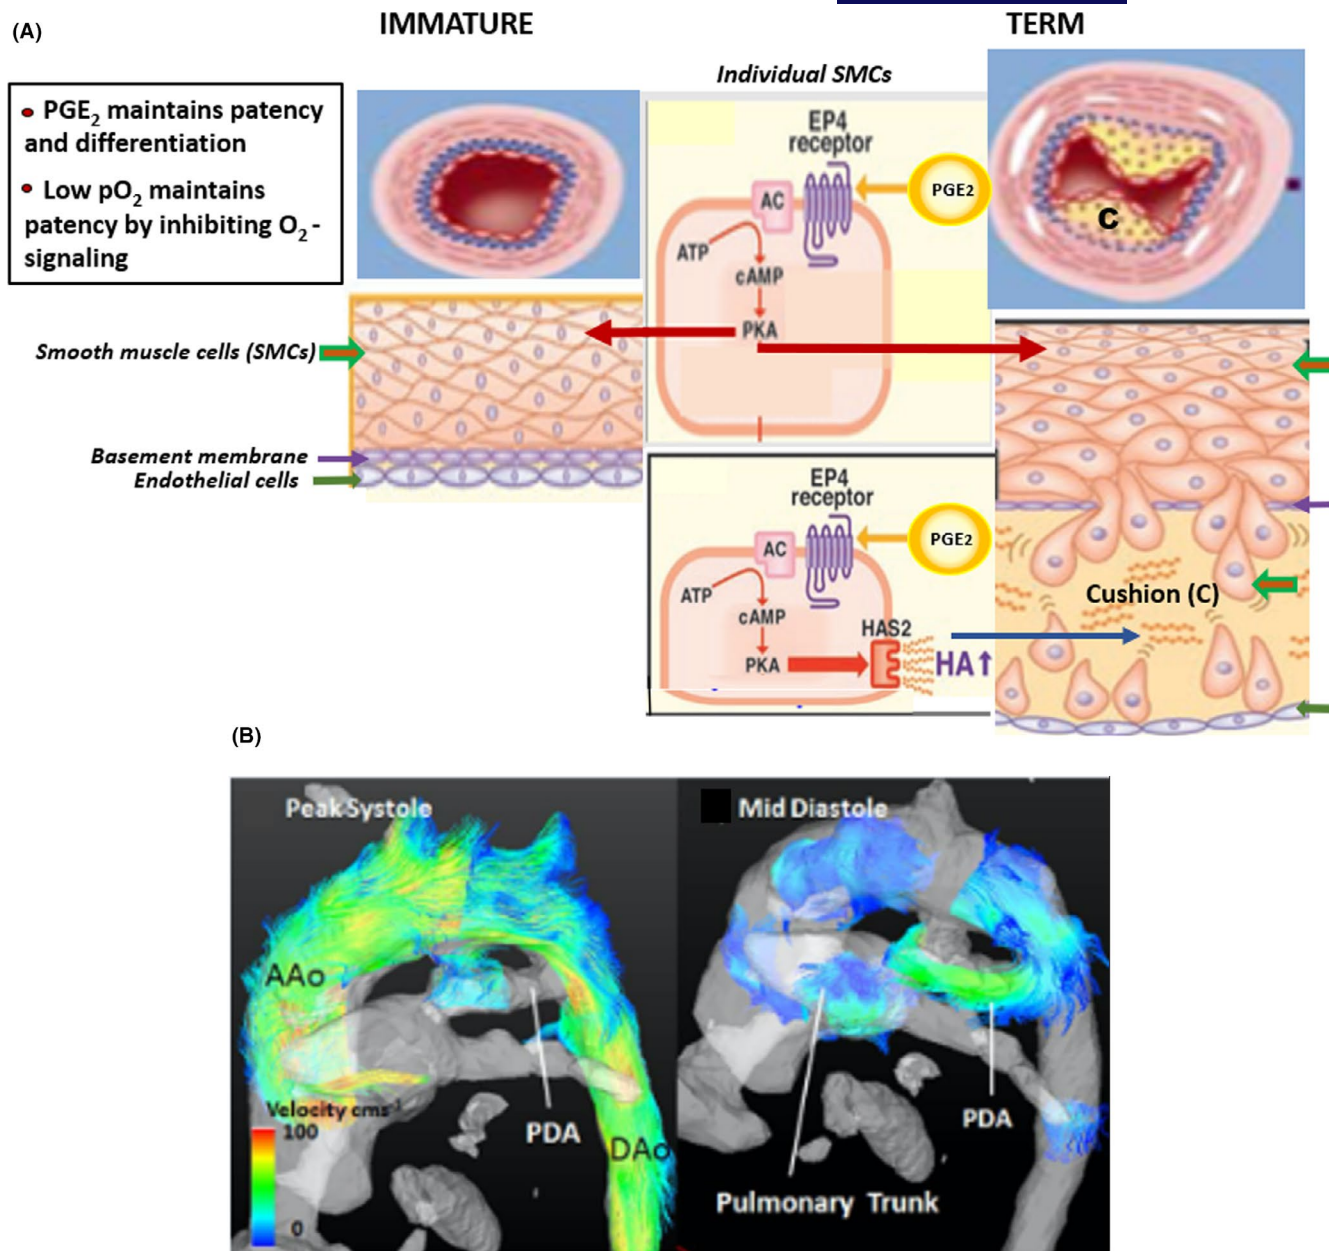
Patent ductus arteriosus (PDA) development in the foetus (A) and visualisation of magnetic resonance (MR) velocity data of the PDA and adjacent vessels (B). (A) Development of the ductus arteriosus. Smooth muscle cells (SMCs) pass through the basement membrane towards endothelium. PGE₂ signalling promotes hyaluronic acid (HA) formation within the developing endothelial cushion, forming mature PDA that is narrowed and readily contracted upon the increase in O₂ tension. Immature PDA has a proportionally large lumen and deficient endothelial cushion. Modified from an article by Yokoyama et al.⁴² (B) Visualisation of the ductal shunt by 3-dimensional MRI velocity data. PDA and thoracic vessels from a very premature infant are depicted during systole (left) and diastole (right). Note that the flow rates within the vasculature (ranging from 0 to 100 cm/sec) are shown without indicating the direction of flow. Modified from an article by Broadhouse et al.⁴¹
